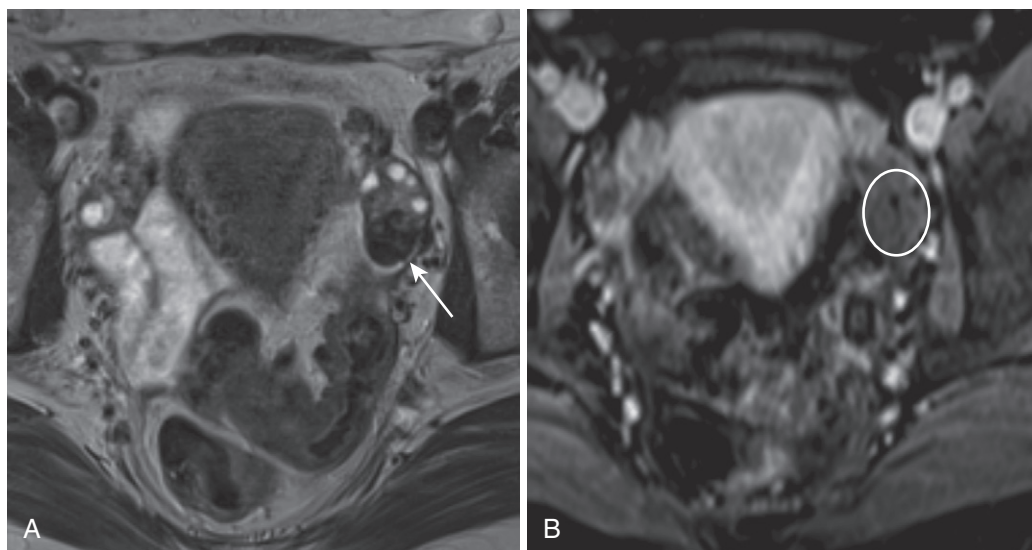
Ovarian fibroma. Axial T2-weighted image (A) shows a small left ovarian fibroma (*arrow* in A) with very low signal and mild enhancement (*circle* in B) on the T1-weighted fat-suppressed enhanced image (B).
